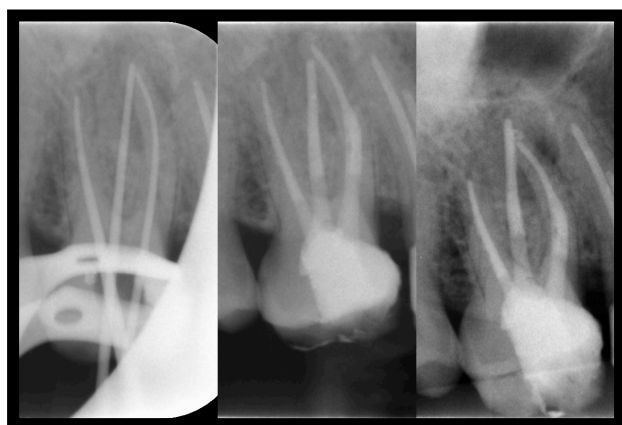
Radiographs from left: Masterpoint, Posttreatment, hyperangulated
